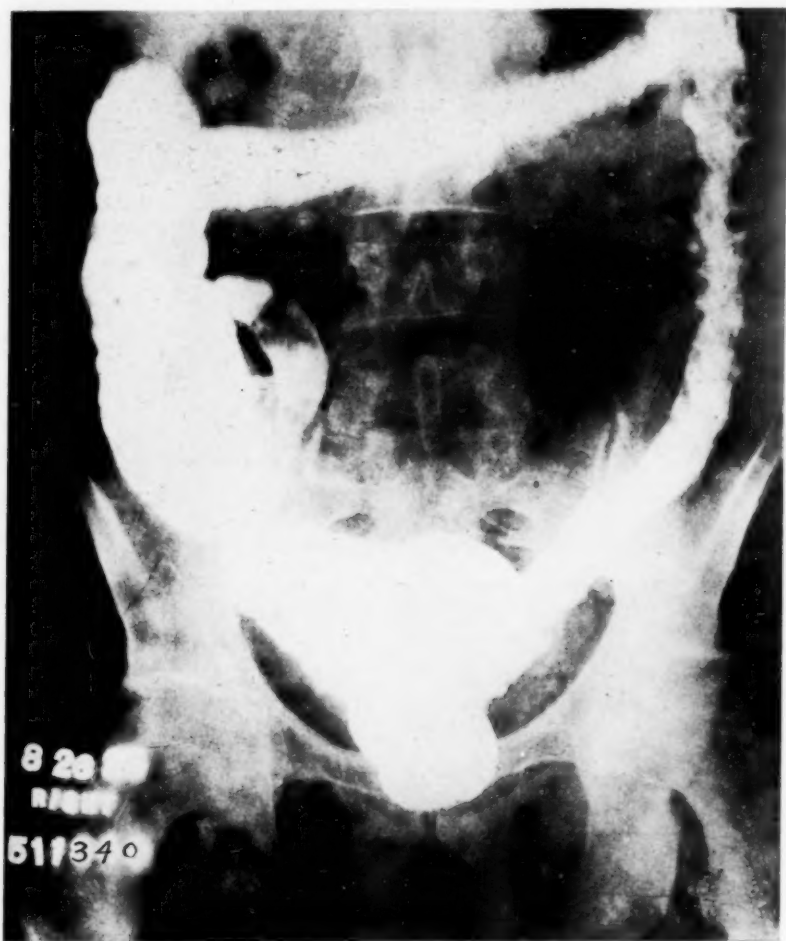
(case 3). Roentgenogram of colon by barium enema. Severe extensive disease with much destruction of mucosa, in August, 1925.
